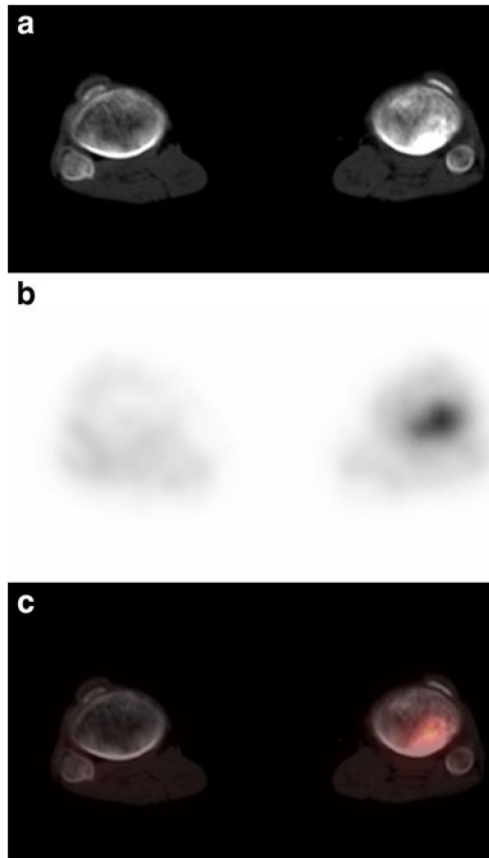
Patient 17: 11-year-old girl with recurrent Wilms' tumor showing focal uptake and sclerotic process in the left proximal tibia; consistent with bony metastatic disease. a Noncontrast transverse CT image of the distal lower extremities (bone window). b FDG PET at same level as a. c Fusion image of a and b
